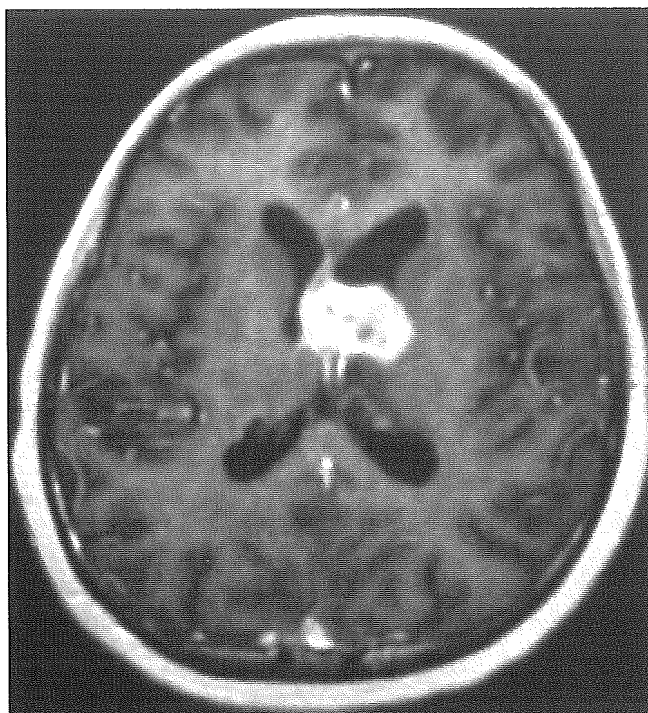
Axial T₁-weighted Gd-enhanced MR image demonstrating a heterogeneously well-enhancing lesion approximately 2 cm in diameter, which is located in the anterior horn of the left lateral ventricle. The mass is attached to the colloid plexus at the foramen of Monro.
